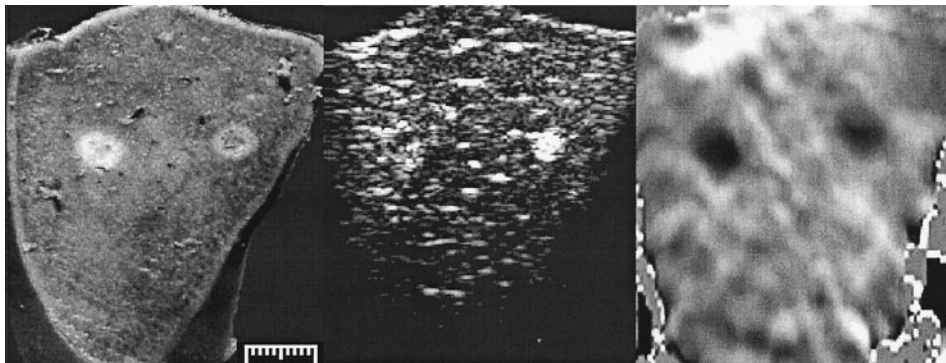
HIFU-ablated circular regions in a canine liver *in vitro*. (Left) Gross pathological view of a cut surface through the ablated regions. (Center) Sonogram obtained from a Diasonics Spectra scanner at 5 MHz. (Right) The corresponding elastogram, where black represents regions with low strain, and white represents regions with high strain. All views are from approximately the same plane. In the elastogram, black = hard; white = soft.
